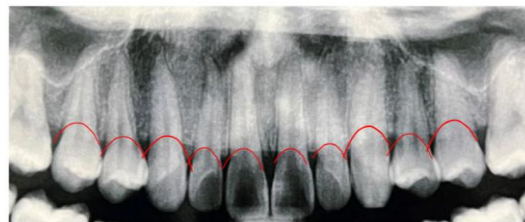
Panoramic radiograph of teeth 15–25. The red line indicates the cemento-enamel junction (CEJ).
